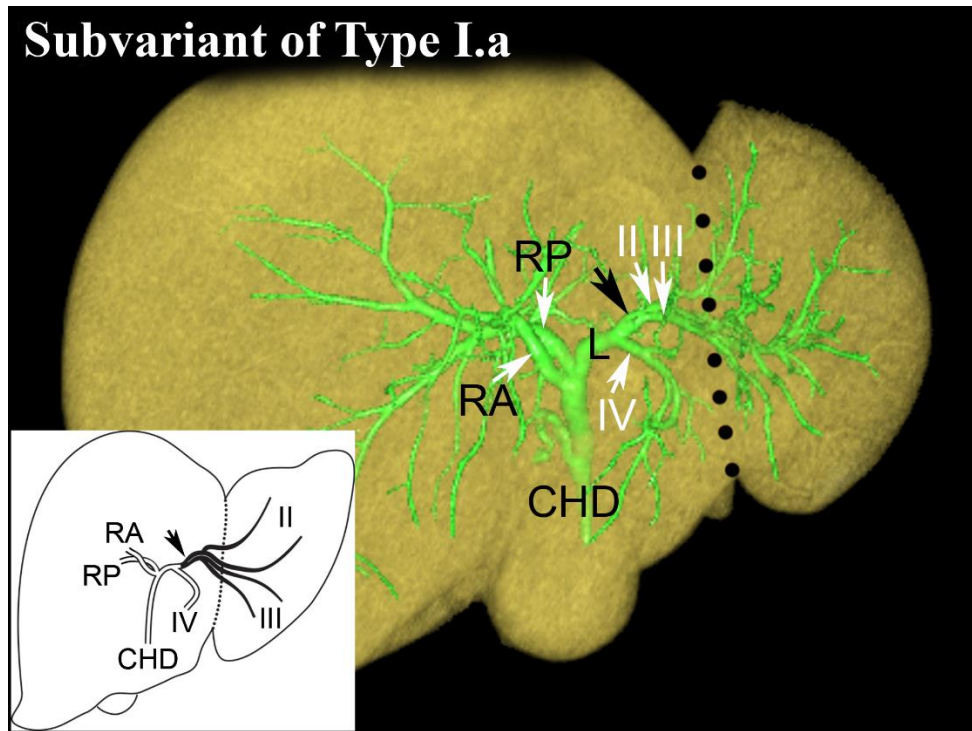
Subvariant of Type I.a. There are more ducts from segment II and segment III as well, which form the LHD close to the hilum, far away from the FL (black dotted line). Black arrow shows the junction of segment II and III ducts. RA, right anterior duct; RP, right posterior duct, L, left hepatic duct, CHD, common hepatic duct. Roman numerals stand for the segmental ducts. (Source: author's own work. Co-workers: András Szuák, Tien Nguyen. CT pictures made by Ibolyka Dudás).
